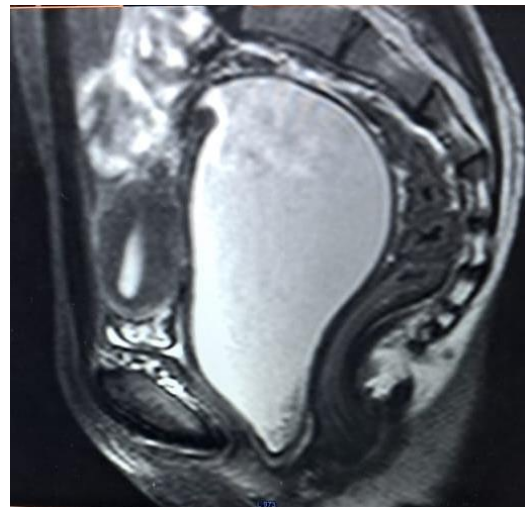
MRI showing transverse vaginal septum with Hematocoplometra (sagittal view).
